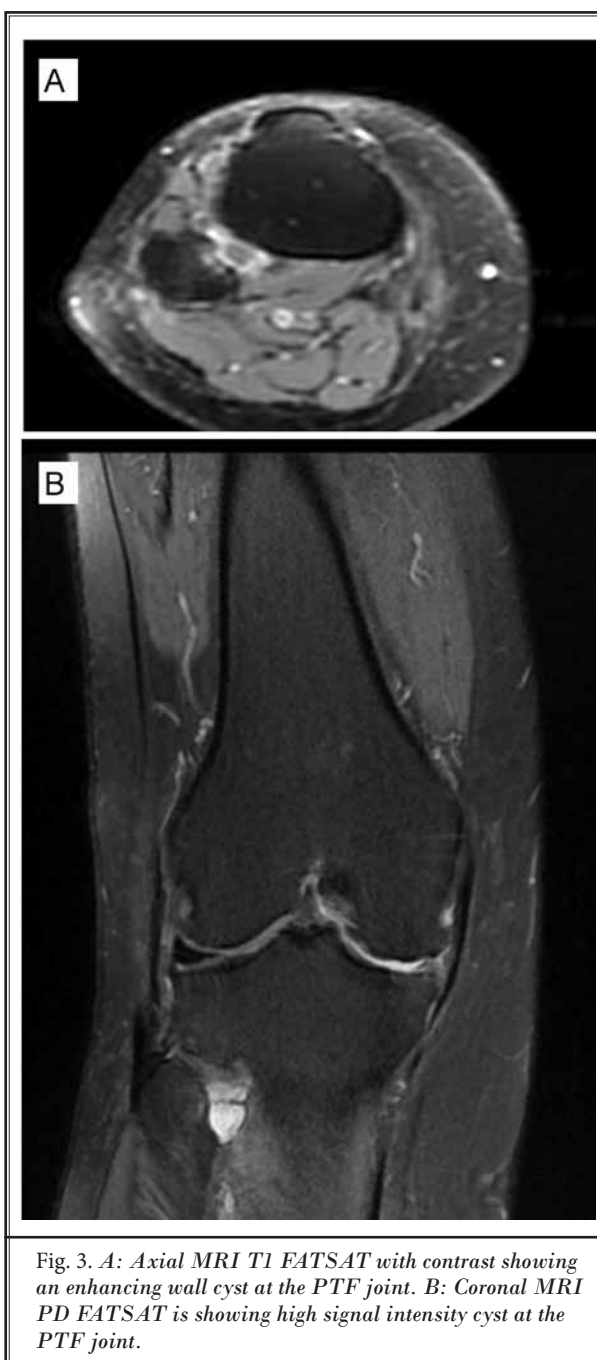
A: Axial MRI T1 EATSAT with contrast showing an enhancing wall cyst at the PTF joint. B: Coronal MRI PD EATSAT is showing high signal intensity cyst at the PTF joint.
